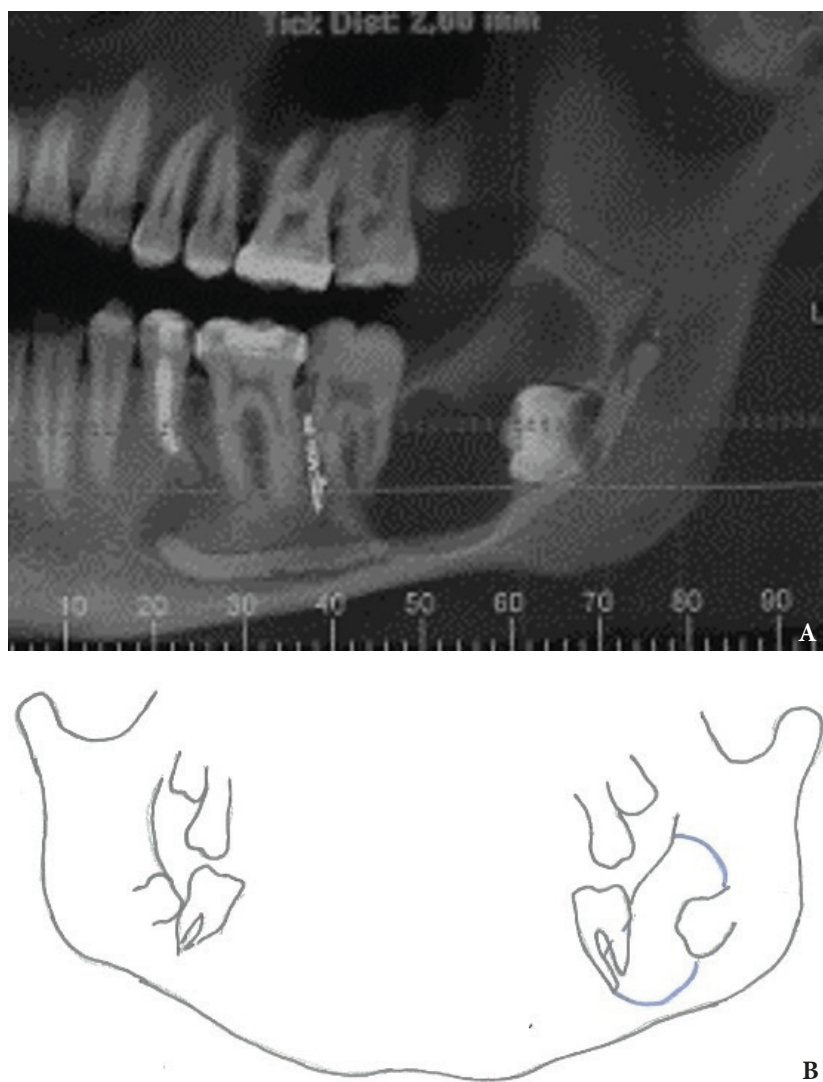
Case 7. A: Initial X-ray. B: Lesion size scheme (*blue*) for resection.
